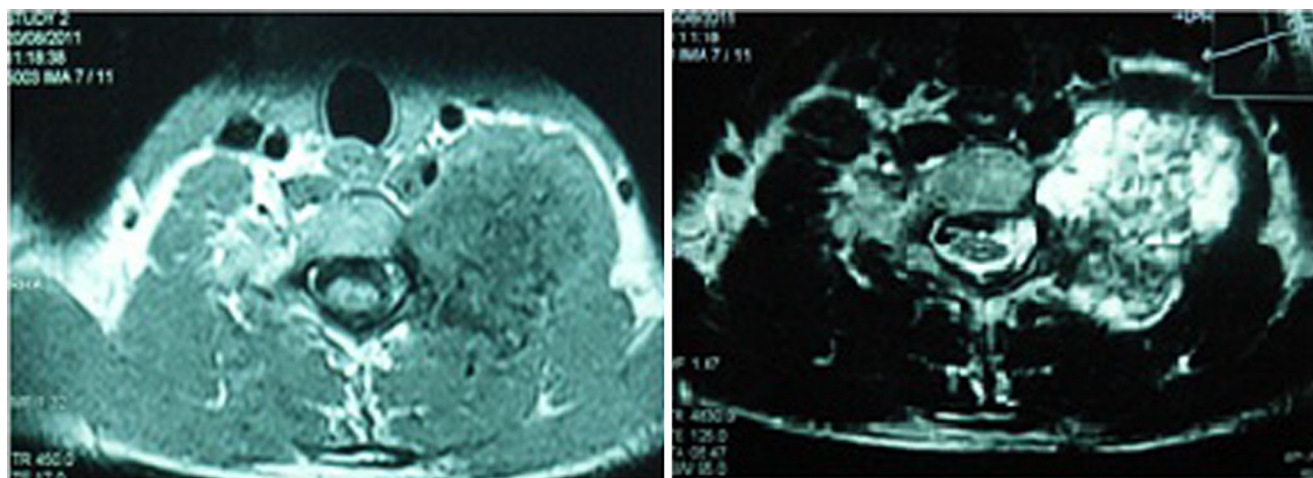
Preoperative imaging by Magnetic Resonance Imaging -T1 weighted image with low signal intensity of the tumour mass arising from C5, C6, C7 and T2 weighted image showing high signal intensity
